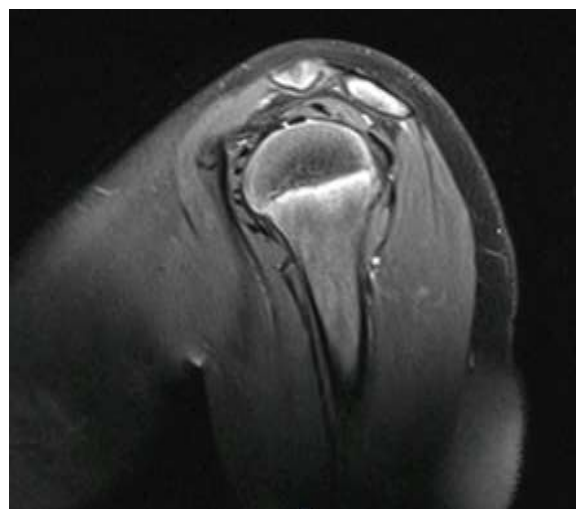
MRI Without alterations
